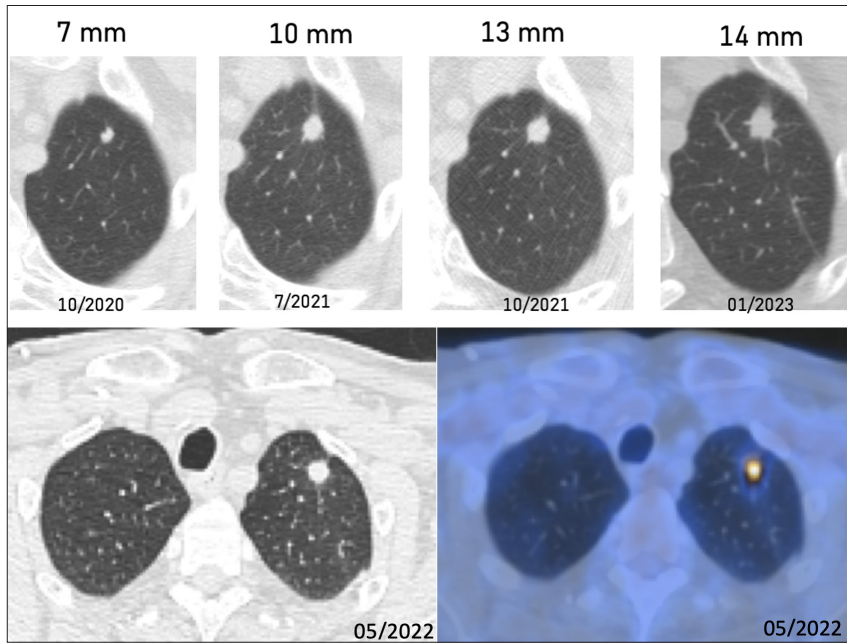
Growing pulmonary nodule in the left upper lobe, intensely hypermetabolic on PET-CT, suggesting metastasis.
